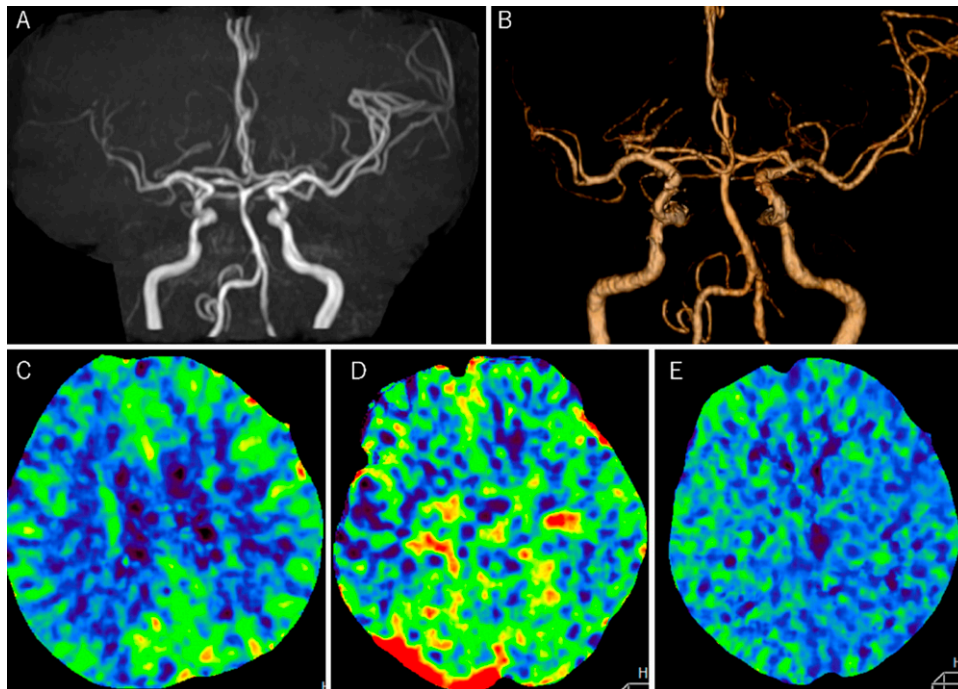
Head MRA and CTA 12 hours after CAS show poor visualization and diffuse vasospasm of the right MCA (A and B). CT perfusion shows that CBF (C) and CBV (D) in the right hemisphere were lower than that in the contralateral hemisphere, whereas MTT (E) was higher.
